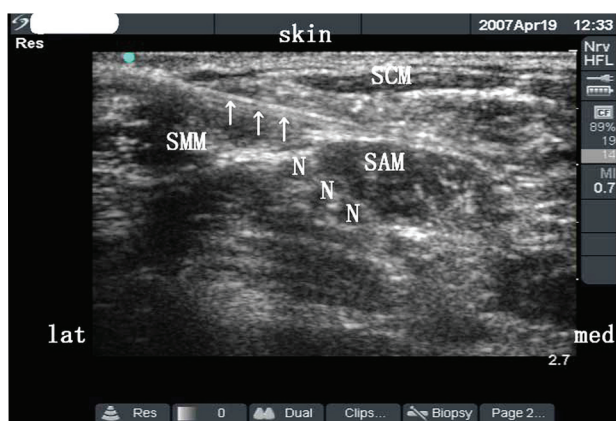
FIGURE Transverse sonogram, at the level of the C-7 vertebra, showing the needle location between the sternocleidomastoid and the scalenus anterior muscles. SCM = sternocleidomastoid muscle; SMM = scalenus medius muscle; SAM = scalenus anterior muscle; N = brachial plexus; ↑ = needle.
